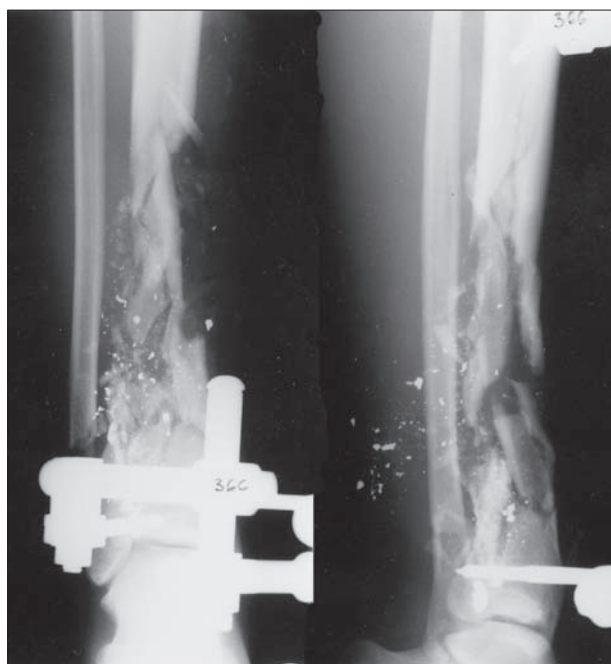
X-rays of the comminuted fracture of the left tibia
